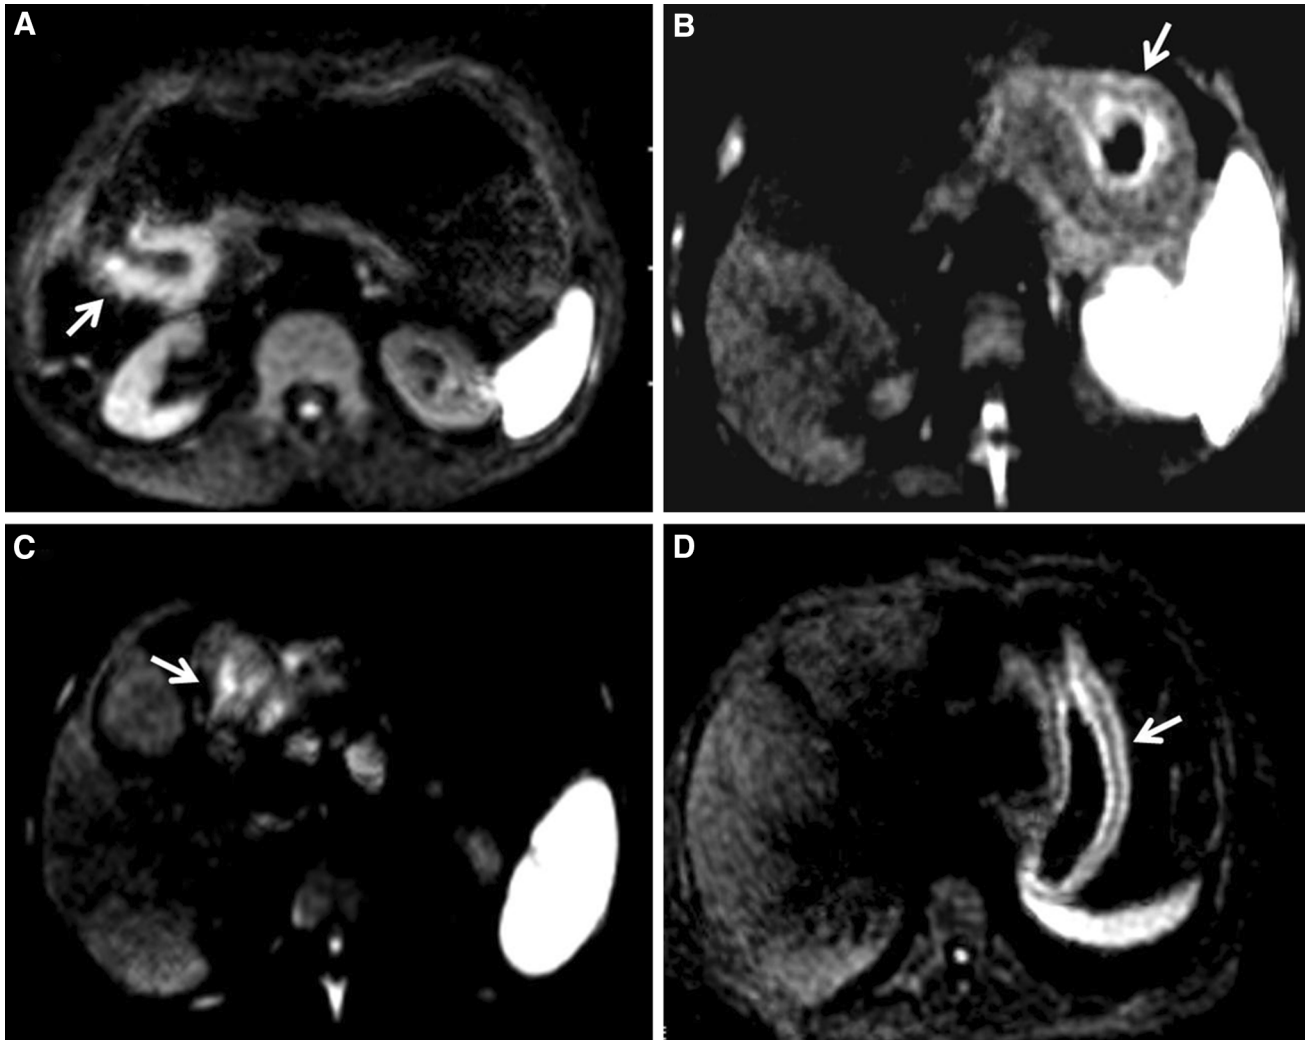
Signal characteristics of gastric cancer on DW-MRI. a Uniformly high signal. b Two-layer type. c Mixed type. d Three-layer type (“Sandwich” sign).
